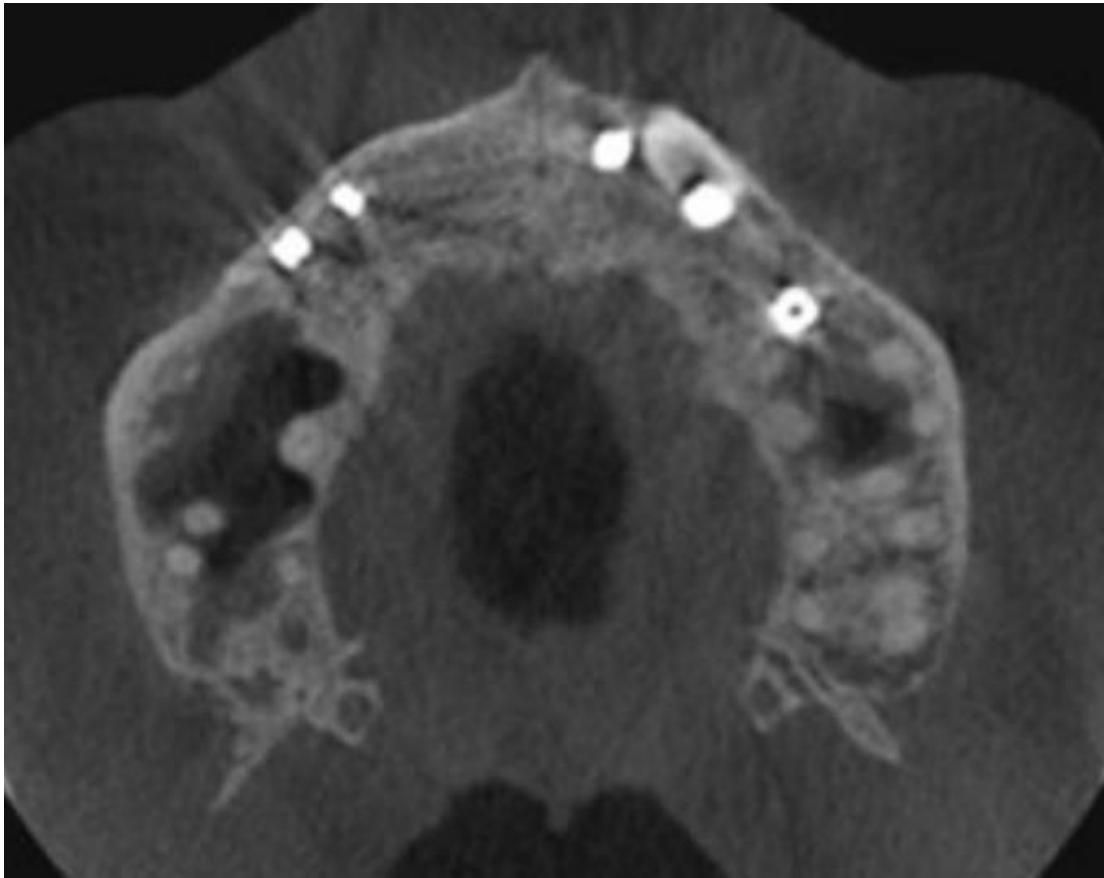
postoperative CBCT image after implant placement
